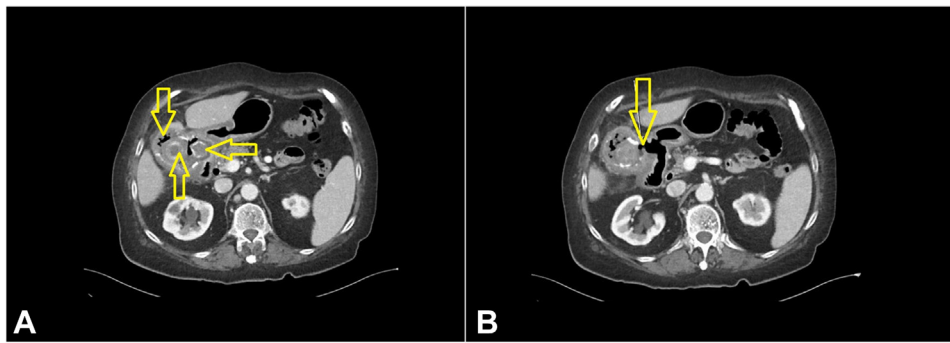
Abdominal CT scan showing emphysematous calculous cholecystitis (A) and a cholecystoduodenal fistula (B).
